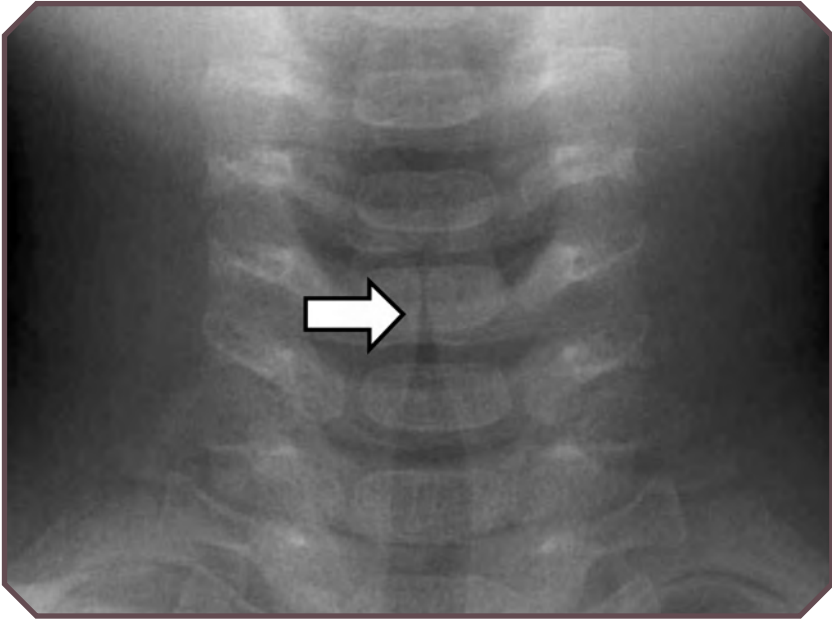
Croup in a 14-month-old girl with cough and stridor. Frontal radiograph demonstrates bilateral, symmetrical subglottic airway narrowing (arrow) consistent with the steeple sign of croup.
